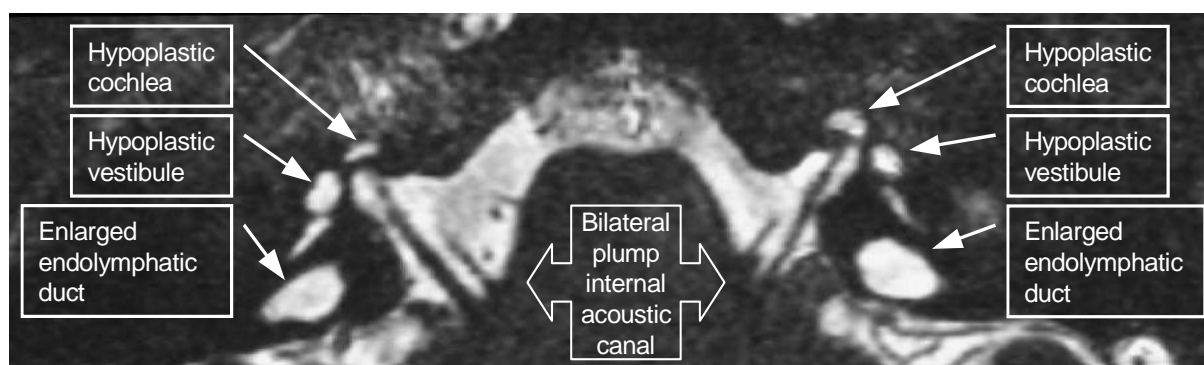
MRI of the temporal bones of case BIV-2 showing a bilaterally plump internal acoustic canal, bilateral hypoplastic cochleas and vestibules with an enlarged endolymphatic duct on both sides. The endolymphatic sac is also bilaterally enlarged (not shown here).
